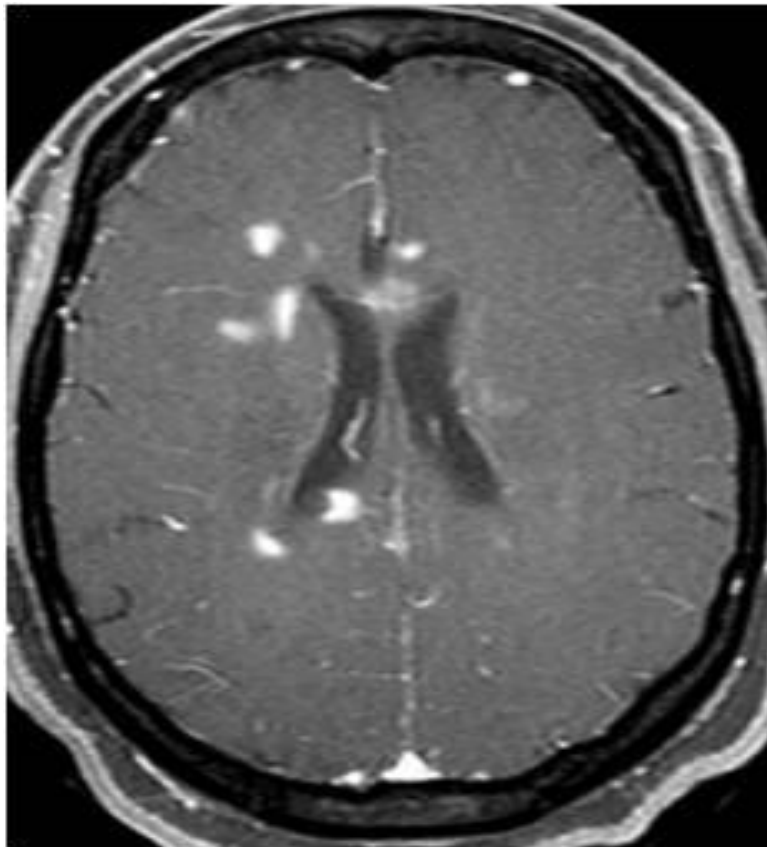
Axial Flair MRI Showing Periventricular Plaques
